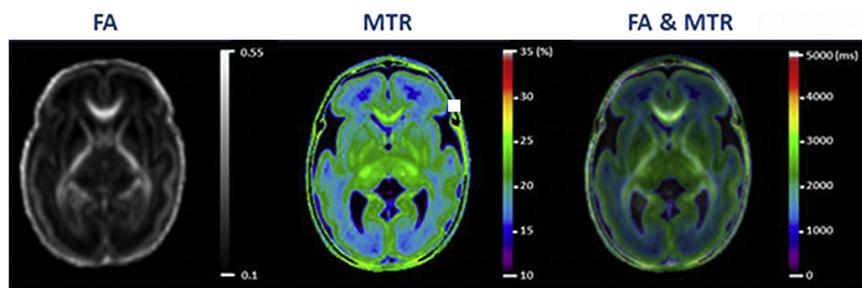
Average FA and MTR maps in 44 preterm neonates. Improved information concerning myelination of the preterm brain can be obtained by combining data from diffusion-tensor imaging (DTI) through which fractional anisotropy (FA; left) values with magnetization transfer ratio (MTR; middle) images; the right image shows the overlap and complementing nature of these 2 MRI sequences. This image was adapted from Nossin et al.³⁶
